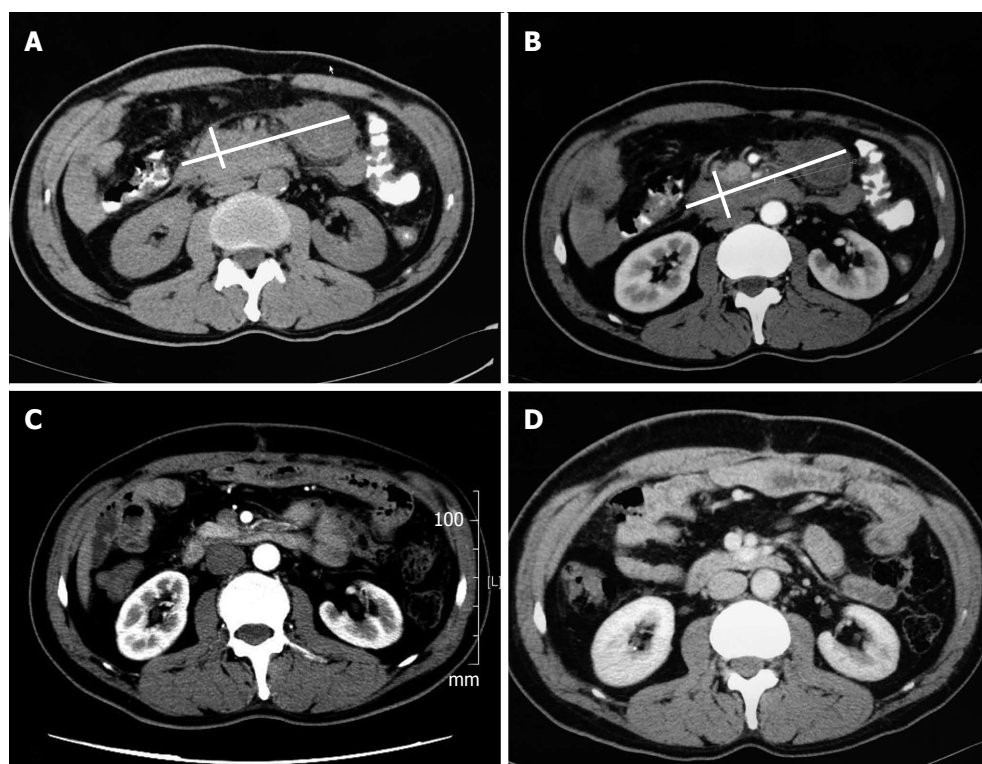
Computed tomography imaging changes of patient No. 1 A: A plain computed tomography (CT) scan on admission showing a large nodular mass (white lines mark the maximum and minimum diameter) located in the upper quadrant of the peritoneum and encasing the surrounding soft tissues; B: An enhancement CT scan showing the mass to be multinodular. Some parts of the mass were mildly enhanced, while others were cystic degenerated; C: A CT scan obtained 3 wk after the operation identified the spontaneous regression of the tumor; D: A CT scan obtained 3 mo later did not show any indication of relapse.
